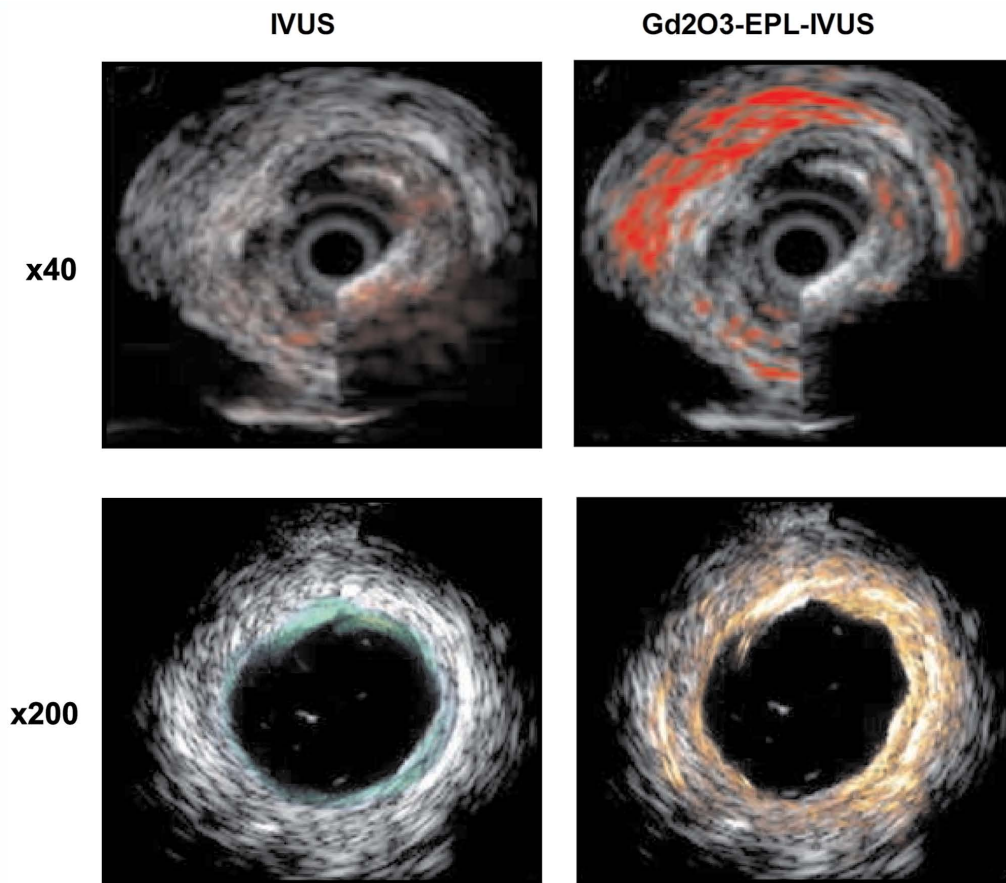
Images of atherosclerotic plaques taken using Gd<sub>2</sub>O<sub>3</sub>-EPL-IVUS or IVUS in the same patient with atherosclerosis. Magnification, x40 or x200. Color indicates the location of atherosclerosis inside the coronary artery. EPL, Eplerenone; IVUS, intravascular ultrasound.
